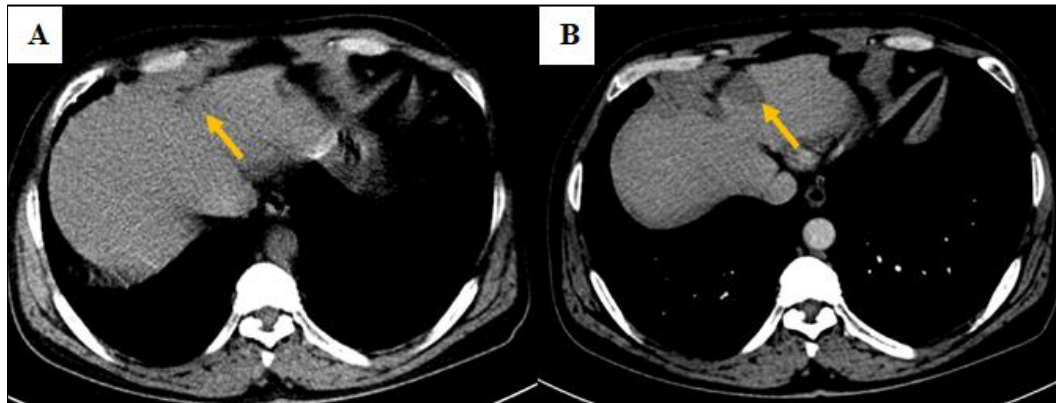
Non-contrast axial CT images (A) showing an isodense hepatic lesion located in the anterior subcapsular region of segment IVa. Post-contrast axial CT images (B) demonstrated no evident enhancement with an attenuation slightly higher than simple water.
